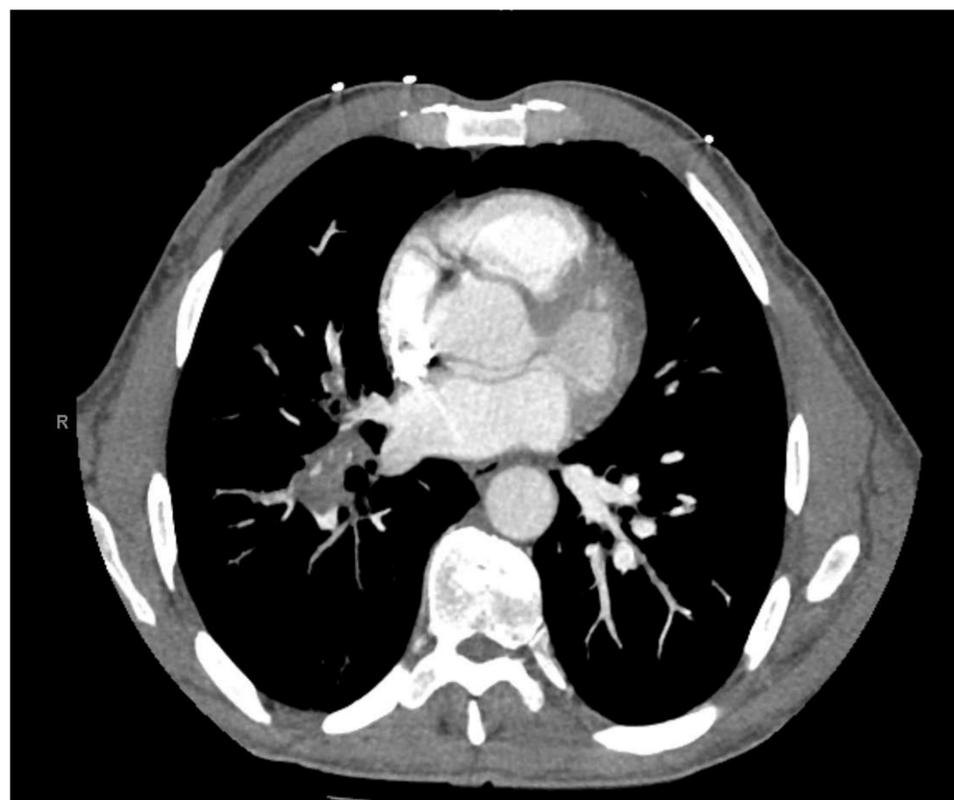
CT Chest with Contrast Demonstrating Right Lobar Pulmonary Artery Emboli
